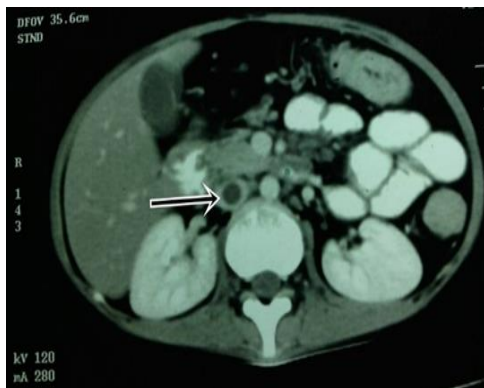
CT abdomen showing thrombus in IVC
